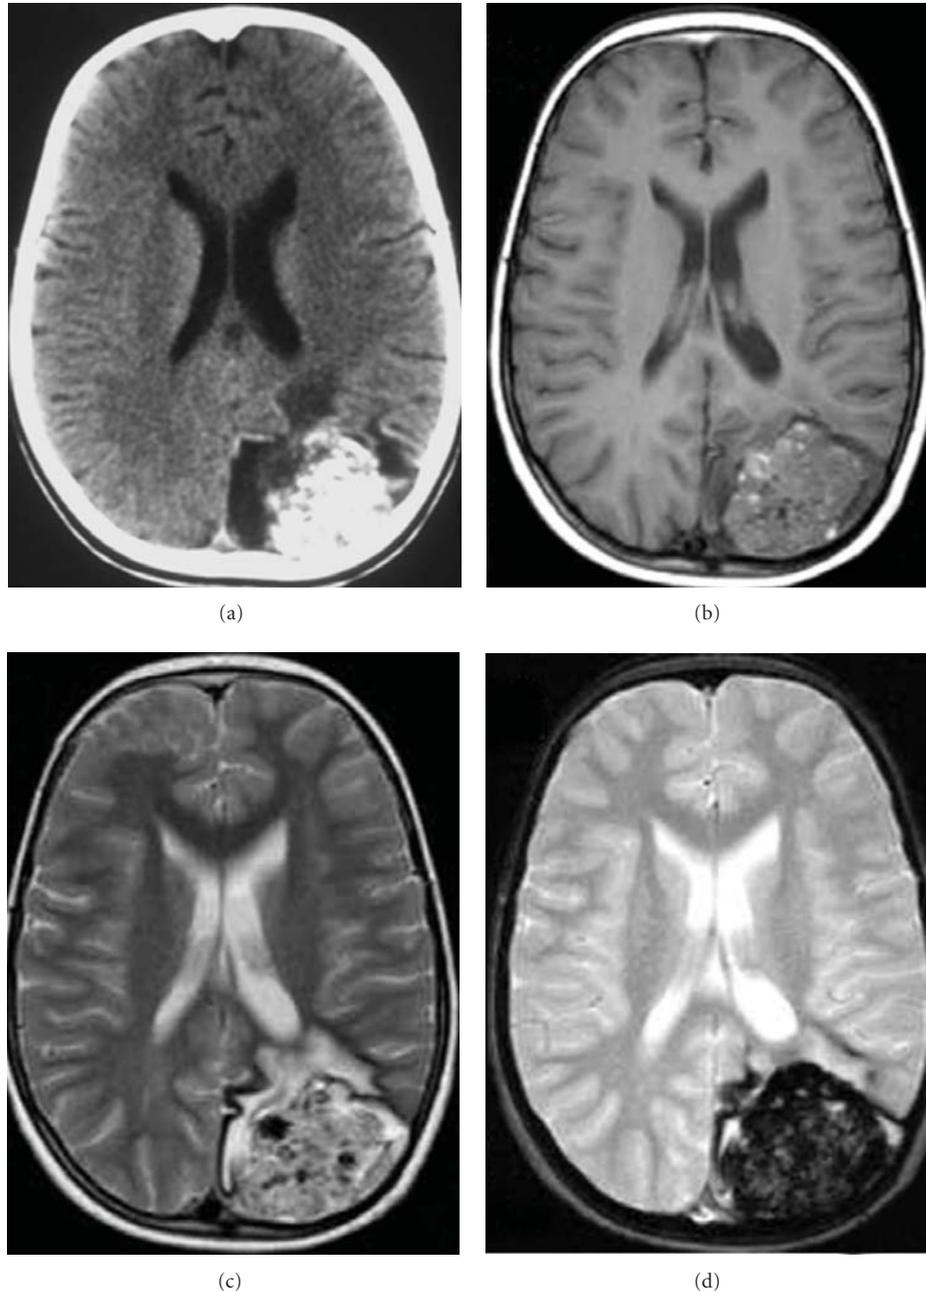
A 5-year-old male with sudden onset of visual defect followed by generalized seizures without previous epileptic history. (a) Plain CT scan showing grossly calcified extracerebral occipital mass with loss of brain tissue. (b) MRI T1-weighted image shows typical “salt and pepper” mixed signal in the mass. (c) MRI T2-weighted Turbo Spin Echo image shows the same mass with features indicating hemosiderine rim and different stages of blood clot. (d) MRI T2*-weighted Fast Field Echo image confirms susceptibility sensitive signal consistent with blood degradation products and different stages of bleeding. All MRI features suggested the diagnosis of giant, mostly extracerebral cavernoma, surgically confirmed.
